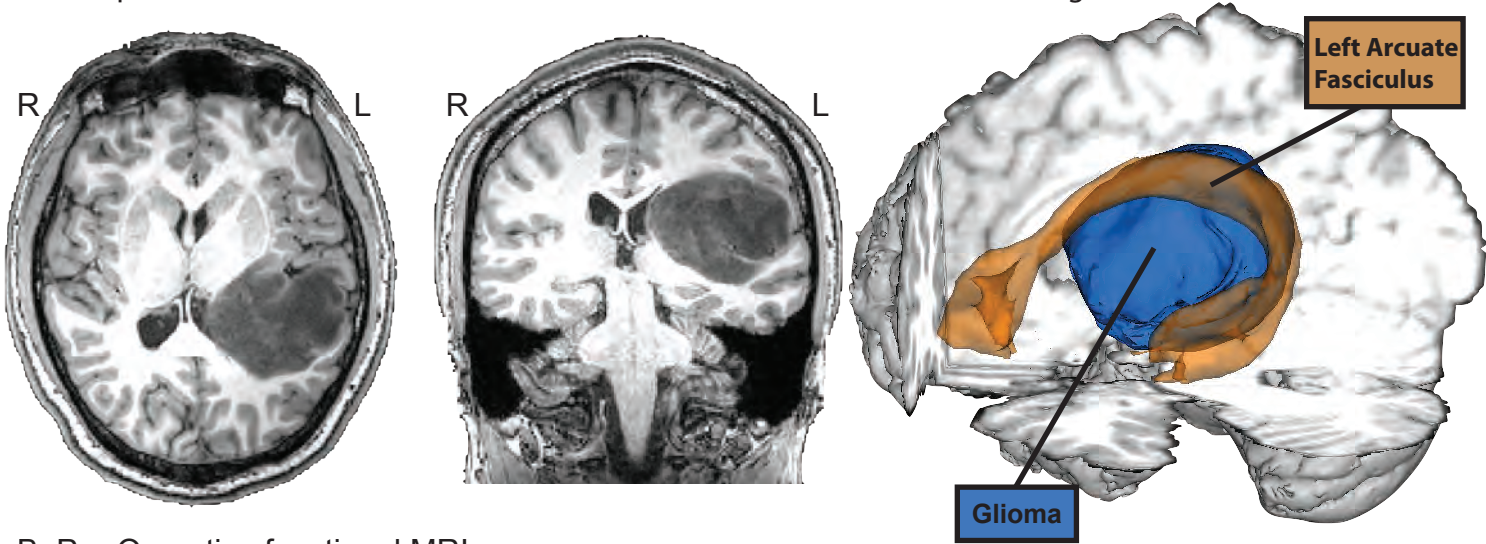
Pre-operative functional MRI and Diffusion Tensor Imaging (DTI) in patient AH with a left inferior parietal glioma that infiltrated the arcuate fasciculus
